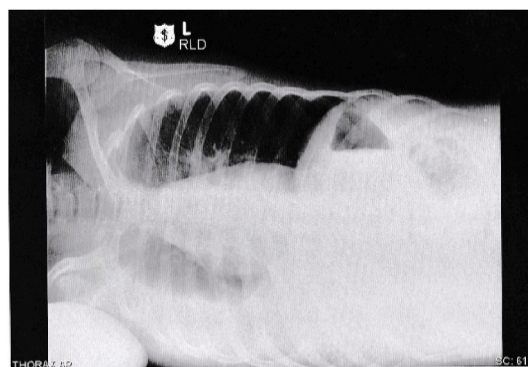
Chest X-ray on 3rd day showed a remarkable pleura effusion with PEI 38.13%.
